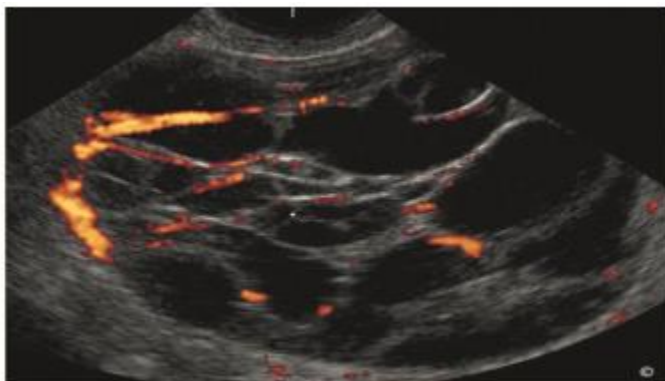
Transvaginal US with high definition color of a borderline mucinous cystadenocarcinoma. Note the presence of multiple thick septations with vascularity noted on color Doppler (20).
